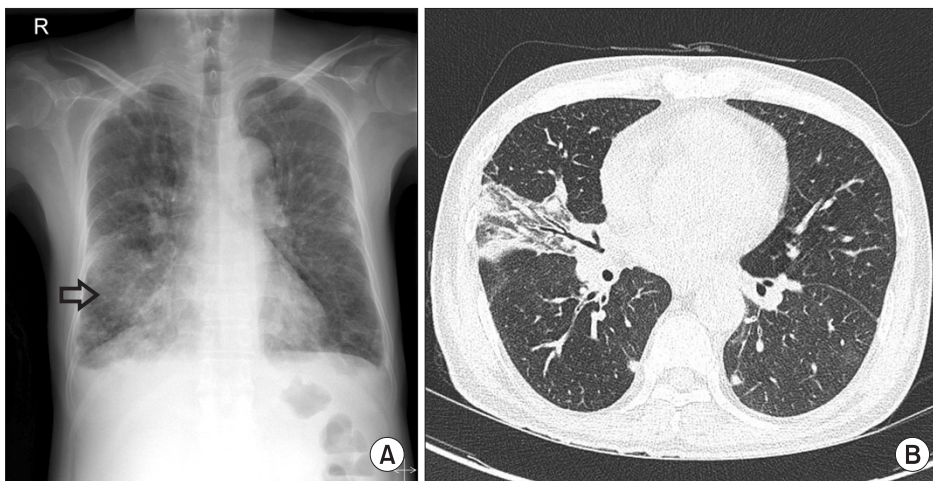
Initial lung images. (A) Initial chest X-ray showed ground glass opacity and consolidation on both lung fields (especially the right lower lung field). (B) Initial contrast-enhanced chest computed tomography showed multiple irregular nodular infiltration in both lungs and patchy consolidation with ground glass opacity in the right middle and lower lungs.
